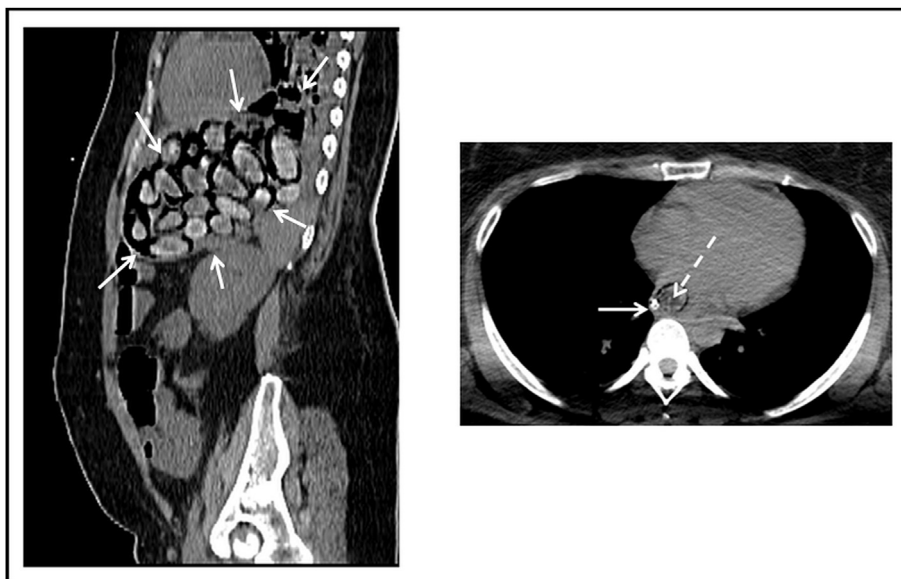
Abdomen computed tomography (CT) performed on admission, with the sagittal view (left) showing multiple packages in the stomach (arrows). The transversal view (right) revealed the presence of a package (dotted line) in the lower oesophagus, across the nasogastric tube (full line).
